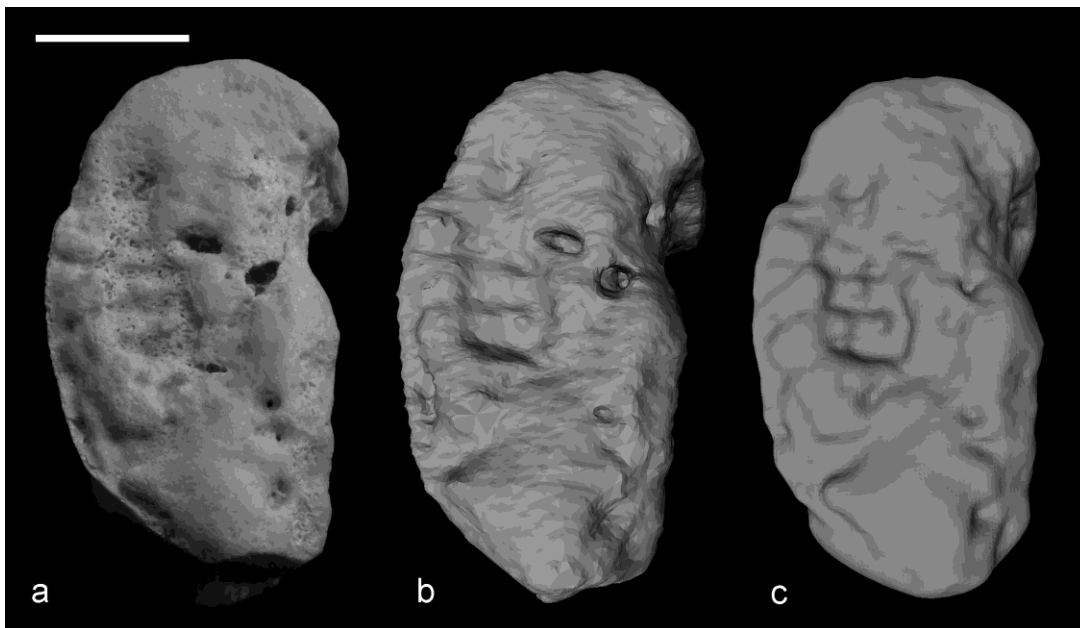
photograph (a), 3D visualization from CT scan (b) and 3D visualization from laser scan(c) of sample 1. Scale bar corresponds to 1 cm
